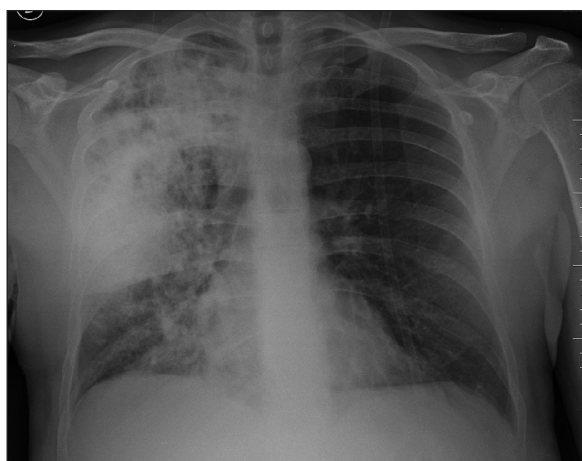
Chest X-ray — alveolar opacity in the upper right lobe
